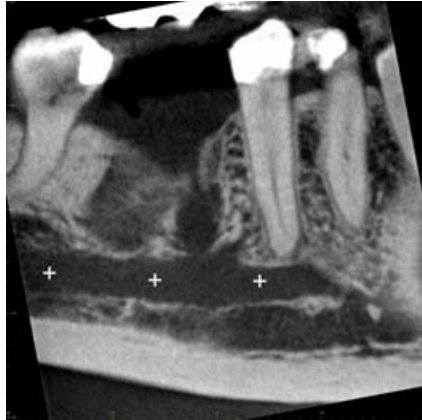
Sagittal CBCT slice
